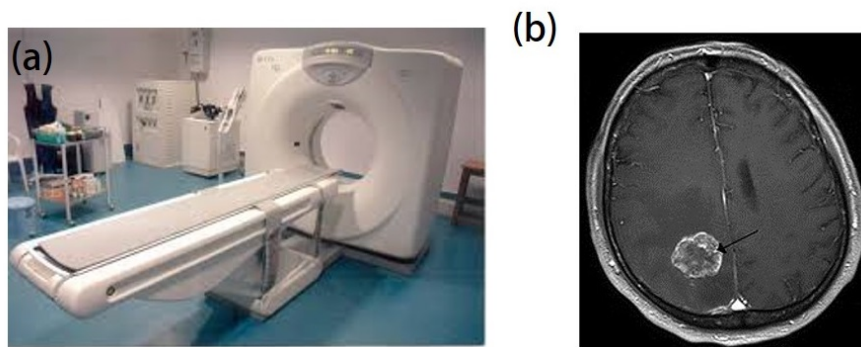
Magnetic Resonance Imaging: (a) outer appearance of MRI; (b) MRI image showing brain metastasis in the right cerebral hemisphere[148].
